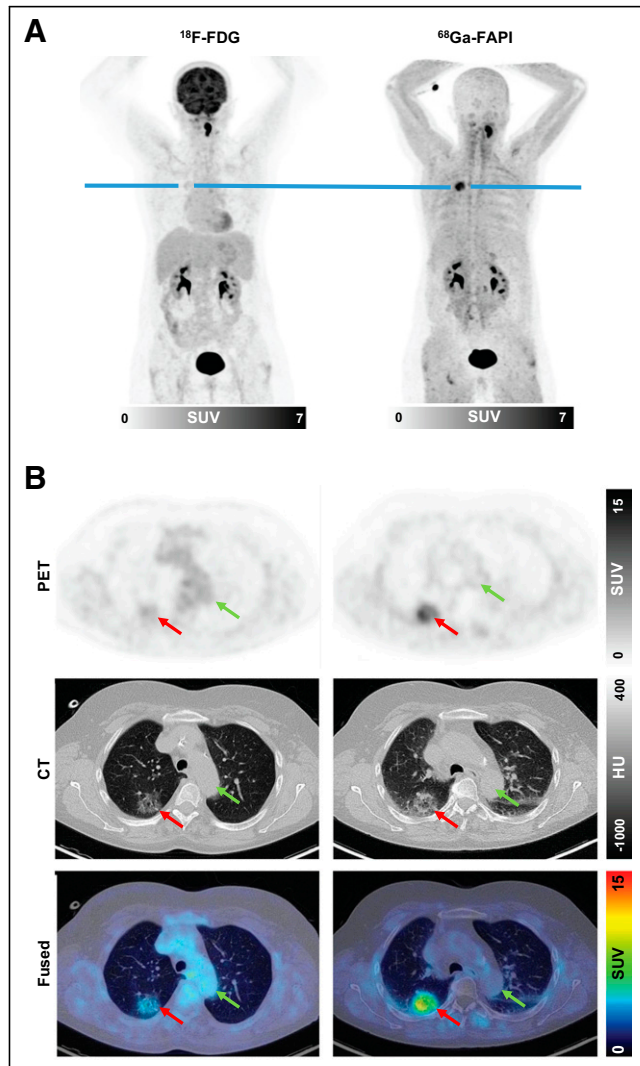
Example ^{18}F -FDG and ^{68}Ga -FAPI-46 images of 51-y-old woman with adenocarcinoma with lepidic growth pattern in right upper lobe. (A) Maximum-intensity-projection PET images. (B) Axial images of suggestive lesion (red arrows) with low CT density in right lower lobe. Green arrows show blood pool in aortic arch. Lesion had ^{18}F -FDG uptake below blood pool niveau but was strongly ^{68}Ga -FAPI-46-positive. CT-guided biopsy led to pathologic diagnosis of adenocarcinoma, and patient was treated by stereotactic body radiation therapy because of functional inoperability. HU = Hounsfield units.
